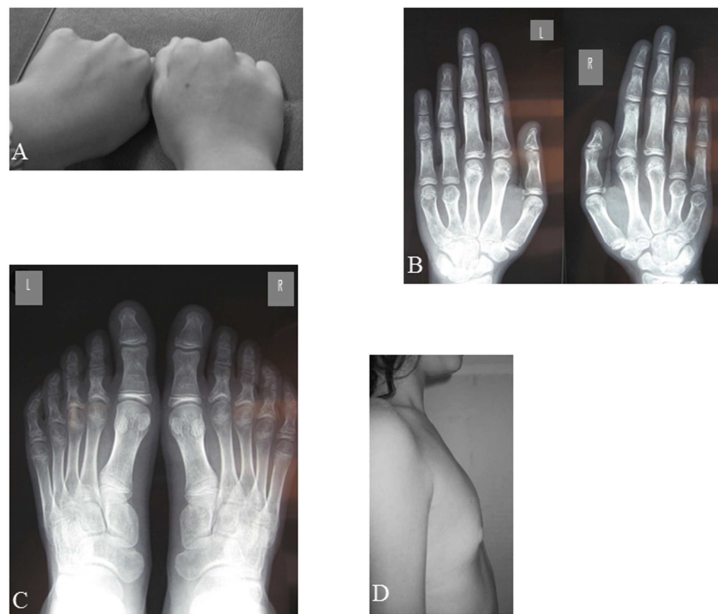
Patient 1. A: Hands: Note the retraction of the fourth and fifth knuckles due to short metacarpals. B: Hand X-rays: note the bilateral shortening of the fourth and fifth metacarpals and the first distal phalanges. Shortened metacarpals show premature fusion of epiphyses. C: Feet X-rays: mild shortening of the fourth metatarsal. D: No breast development at the age of 12.8 in spite of uterine length of 54 mm and serum estradiol levels of 162 pmol/L.
